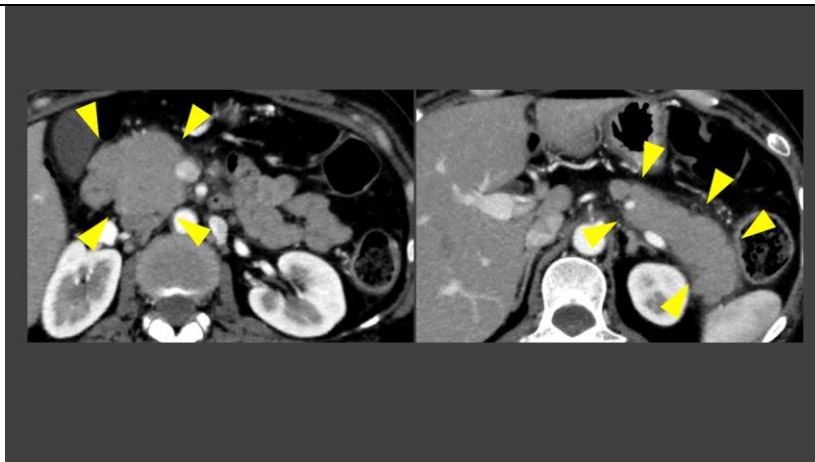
Abdominal contrast-enhanced computed tomography in pancreatic phase showed diffuse swelling of the pancreas (arrowheads) and a thin hypodense area surrounding the pancreas, with a capsule-like structure.
